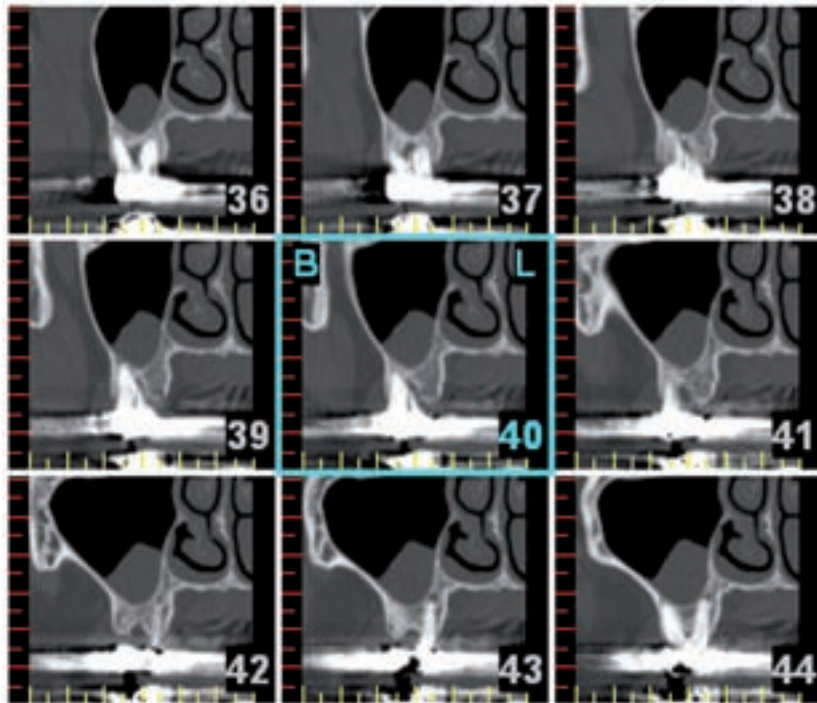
Periapical pathology extending into the sinus.
